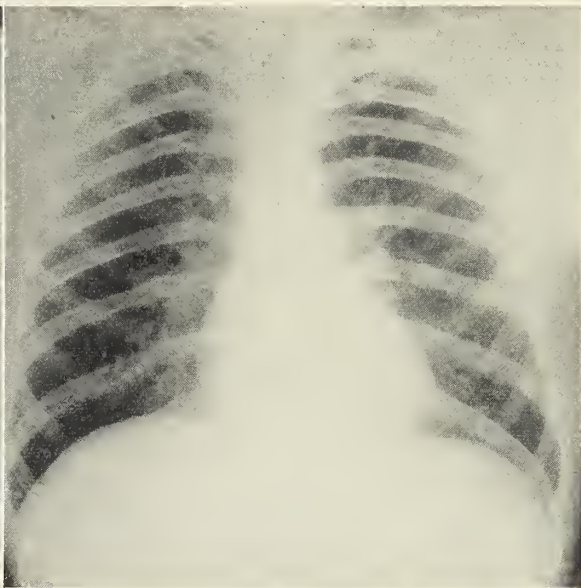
Radiograph taken April 25, 1933, showing recession of involved area.
